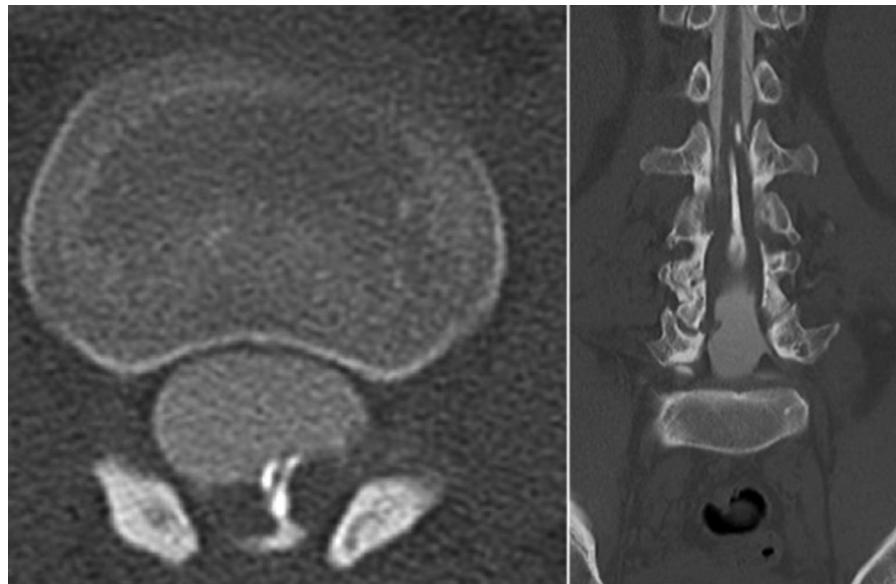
Axial (Left) and coronal (Right) CT images showing dense contrast filling the space between the hemicords.
